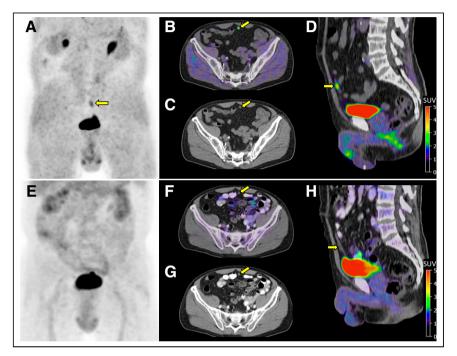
Maximum-intensity projections (A and E), fused PET/CT axial images (B and F), CT axial images (C and G), and fused sagittal PET/CT images (D and H) demonstrating mild 68 Ga-FAPI-46 uptake (SUV_{max}, 4.1; A–D) and no 18 F-FDG uptake (E–H) in a cystic structure of a urachal remnant (arrows).
